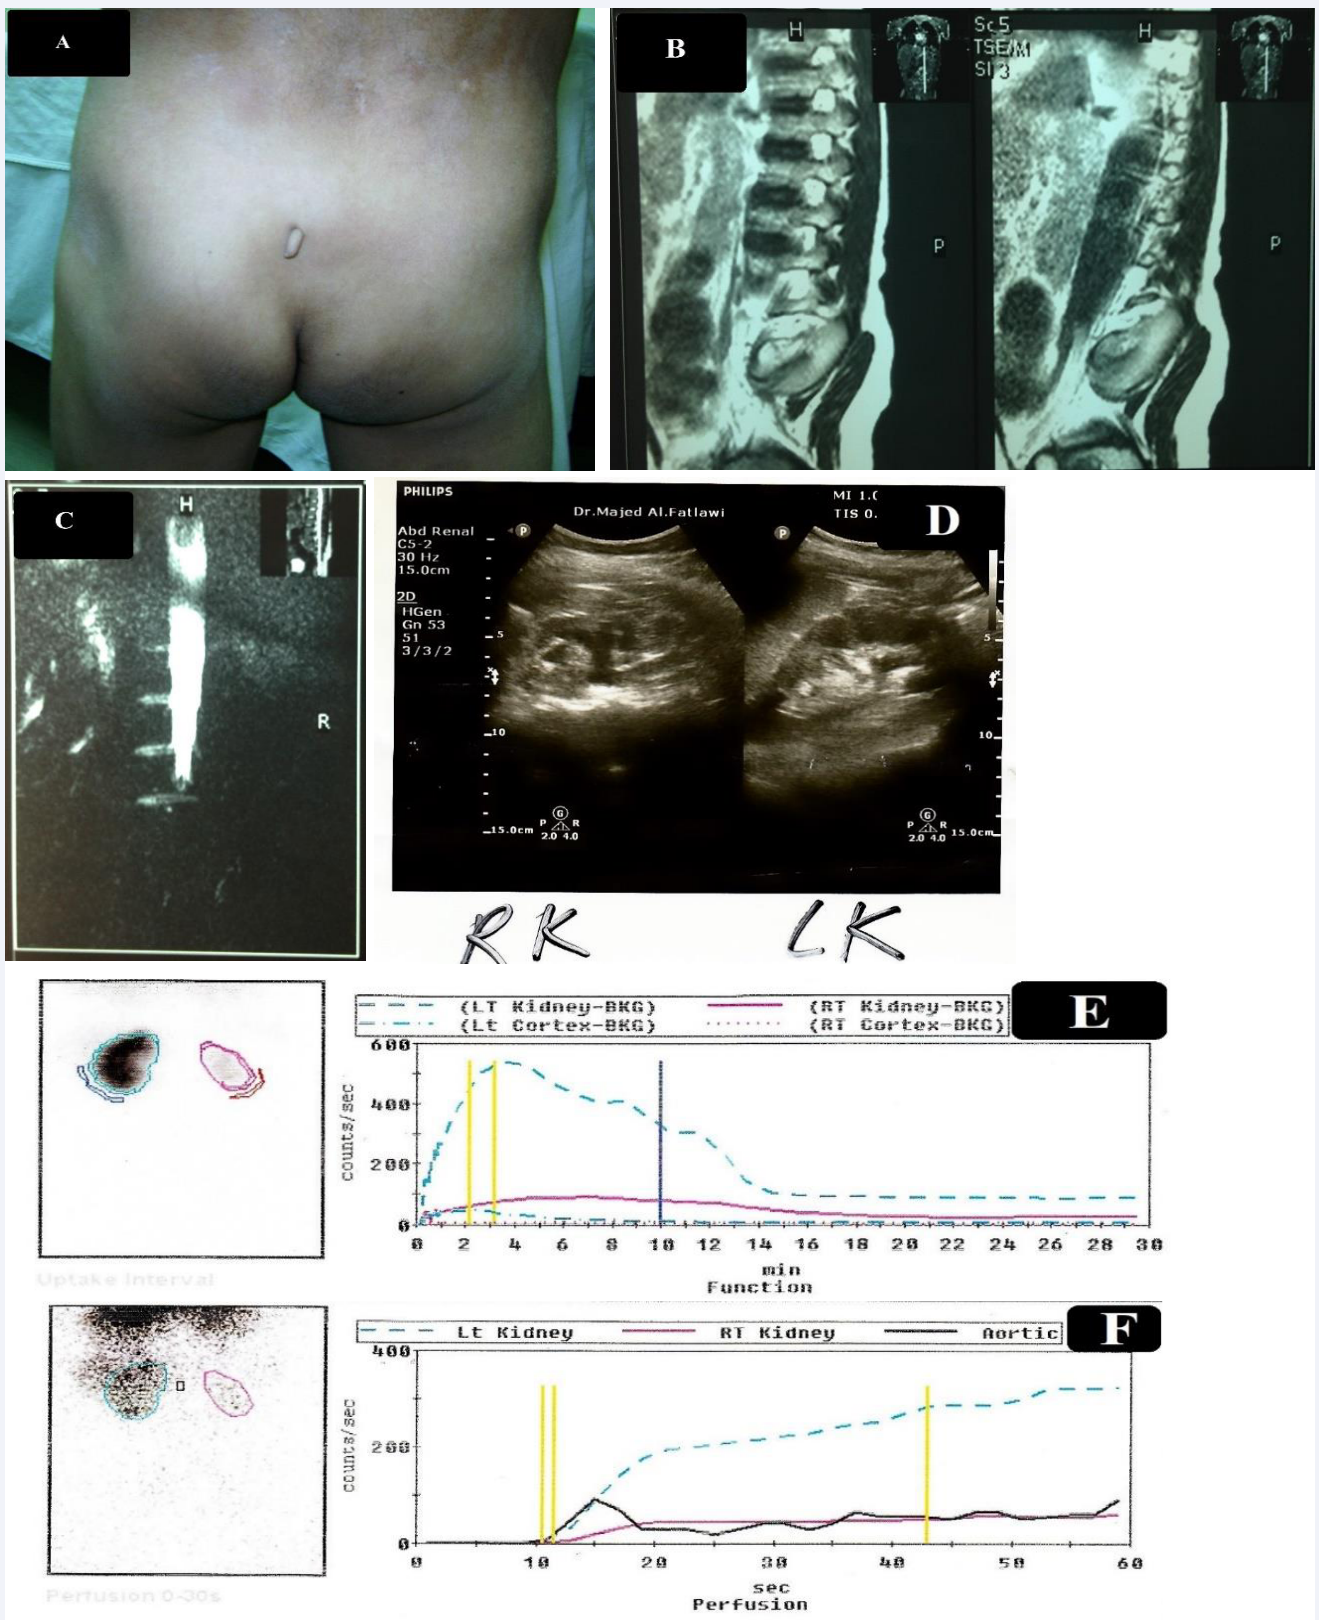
A, B, C, D, E and F; A: Flat buttock with sacral dimple. B&C: MRI of the lumbosacral vertebral column revealed an abruptly and high-ending conus, sacroccygeal hypoplasia, including the absent S3–5 and coccygeal segments with dysplastic S1 and S2 (Renshaw type 1). D: Ultrasound image assessments reported the images of the neuropathic bladder with evidence of reflex uropathy, small right kidney with decrease in the parenchymal thickness and bilateral pyelonephritis changes. E&F: Diuretic Reno gram (135MBq Tc99m MAG3) submitted poor function of right kidney; the split function was 10%.
